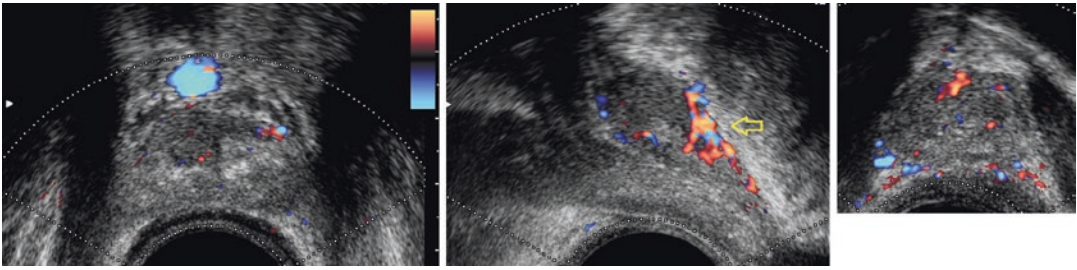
Eco-power Doppler images 18 months after cryoablation, showing absent vascular signal and residual viable tissue in the anterior zone in fibromuscular stroma (*middle*)
